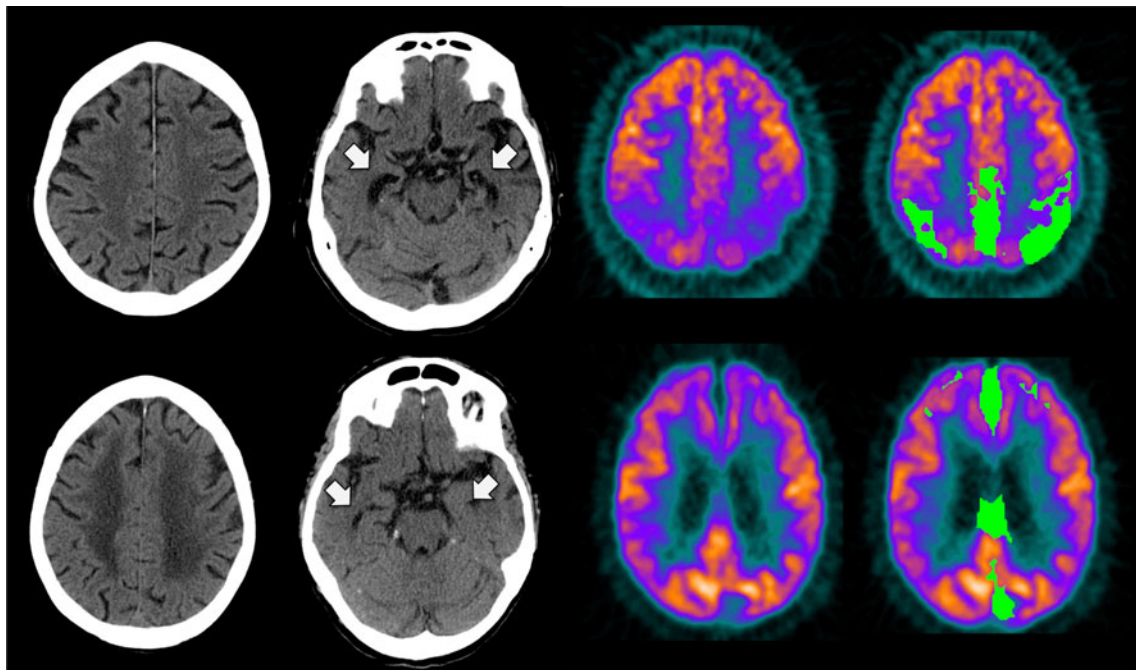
Typical examples of Alzheimer disease (AD) (*top*) and vascular dementia (VaD) (*bottom*). Typical non-enhanced axial CT of an AD patient with focal atrophy of the hippocampus leading to dilation of the temporal horns of the lateral ventricles (*arrows*) and subtle biparietal atrophy. FDG-PET images show the typical hypometabolism of the posterior cingulate gyrus/precuneus and of the parietal and temporal cortex, bilaterally. These changes are visible on radioactivity distribution
